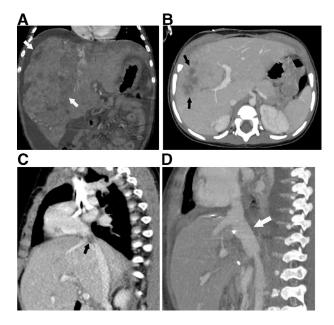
(a) Enhanced CT coronal reconstruction at presentation showed a large hepatic mass (arrows) associated with intra-abdominal free fluid. (b) The lesion showed good response to chemotherapy with decrease in size (arrows). (c) Despite the decrease in size there was still vascular invasion of the IVC (arrow). (d) Enhanced cororal CT reconstruction after an extended right hepatectomy. The upper portion of the IVC was reconstructed with a surgical conduit (arrow).
